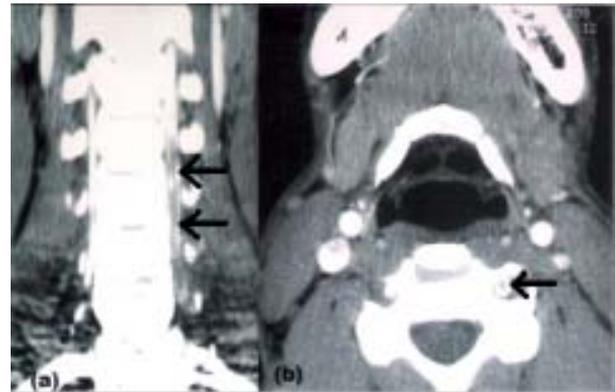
CT Angiogram (a) coronal view of left vertebral artery showing filling defect (arrows) in segment II (C6 to C2) (b) Axial view of enlarged left vertebral artery with filling defect (arrow).
